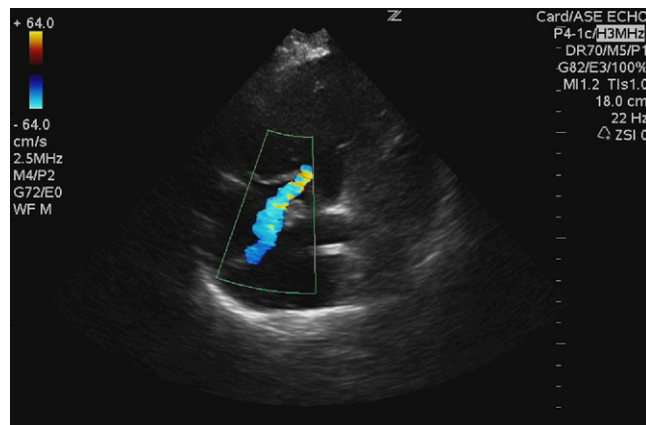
Tricuspid regurgitation jet observed with color flow Doppler. Used with permission of James Q. Hwang, MD, Department of Emergency Medicine, Brigham & Women's Hospital, Boston, MA.
